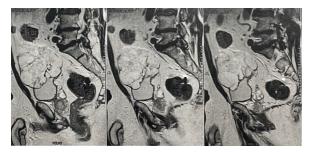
Magnetic resonance imaging showing injury (Source: Personal collection).
